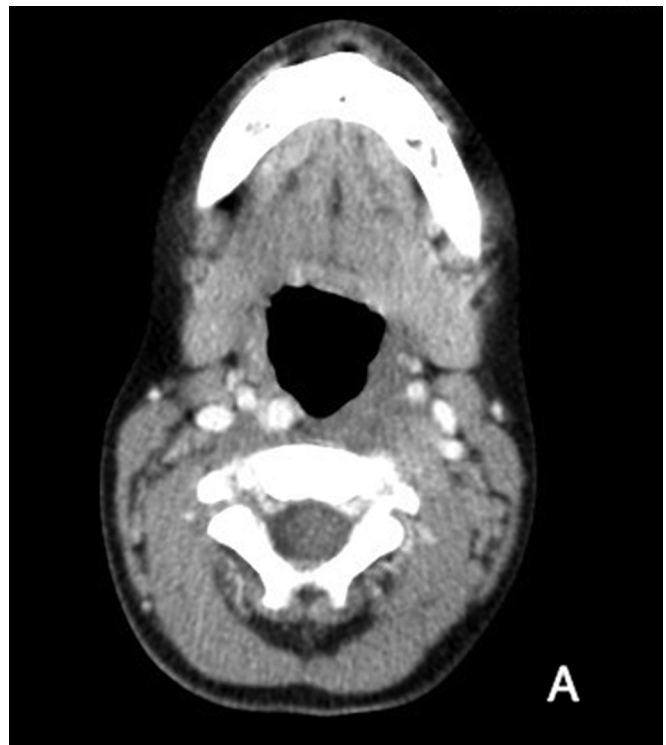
CT neck with contrast, performed on postoperative day 15. Selected axial image demonstrates asymmetric low attenuation soft tissue swelling involving left parapharyngeal and retropharyngeal spaces and left carotid space, without fluid collection or rim enhancement (A). Medial deviation of the right common carotid artery (B) and right internal carotid artery (A) is observed in the right parapharyngeal and retropharyngeal locations, an anatomic variant. Medial deviation also involves the left common carotid artery into the left retropharyngeal soft tissues, an anatomic variant (B). CT, computed tomography.
